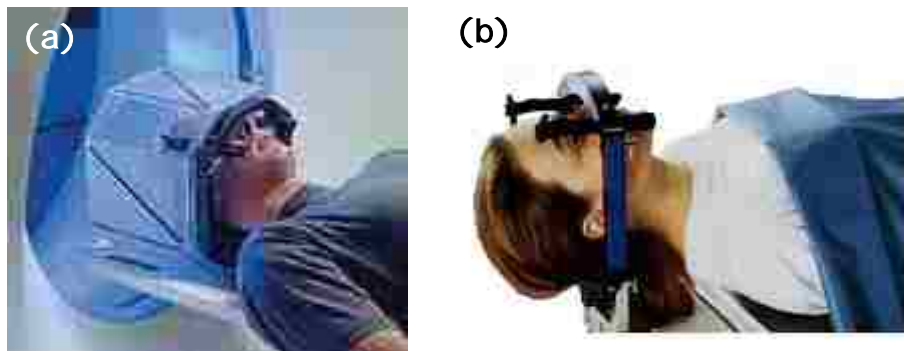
(a) CT stereotactic localization box mounted to stereotactic head ring. Fiducial rods along the localization box define the stereotactic coordinate system in the treatment planning system. (b) Stereotactic Head Ring. The head ring bolts rigidly secure to patient's forehead and mounts to treatment couch. (from www.nebraskamed.com)
